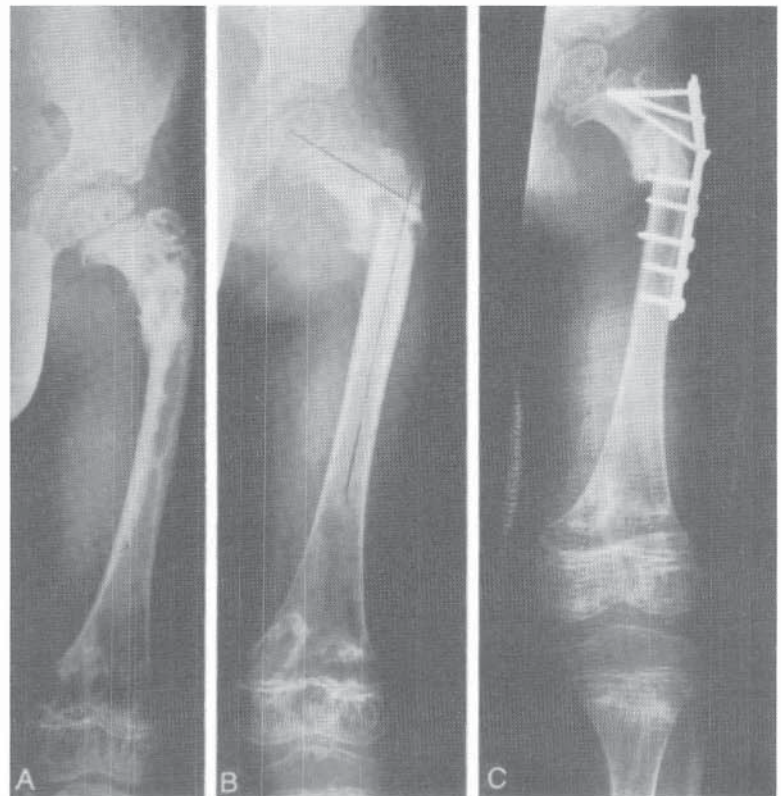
Subtrochanteric pathologic fracture in Ewing's sarcoma of the proximal femur treated by internal fixation with plate and screws. A, Prefracture radiograph showing the sclerosis and radiolucent changes in bone. B, AP radiograph of the femur showing the subtrochanteric pathologic fracture. C, Postoperative AP radiograph. Internal fixation with plate and screws was used.
